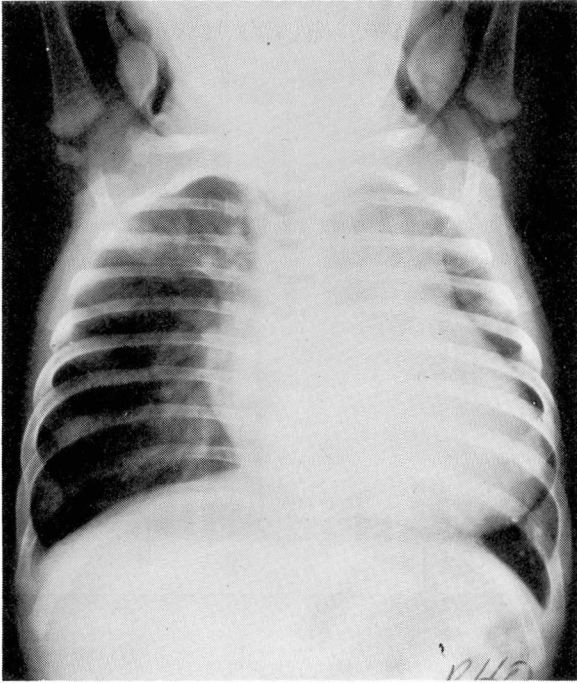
Case. 1. Roentgenogram of the chest, demonstrating massive emphysema of right middle lobe with cardiac enlargement.
